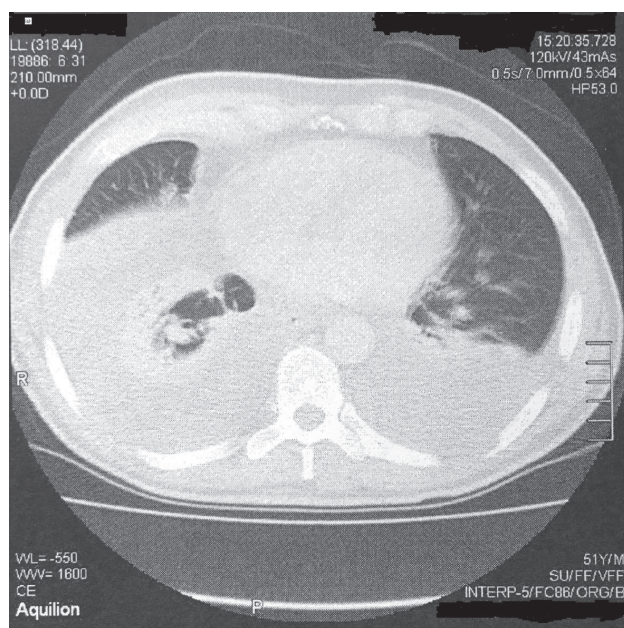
Chest CT demonstrates a large right pleural effusion and a small amount of pleural effusion at the left side, both causing atelectasis in the lower lobes.
